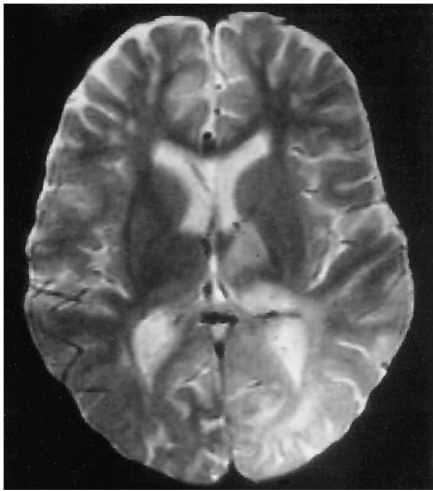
A 9-year-old boy with a 5-month history of SSPE, clinical stage G:IIA. An MR study obtained at admission (not shown) revealed only mild focal subcortical high-T2 white matter changes. Four months later, with the patient at clinical stage G:IIIB, T2-weighted (2000/80/1) MR image shows progress of high-intensity white matter changes, slight atrophy (MR stage 3), and extensive gray matter changes involving the left temporal (not shown) and parietooccipital regions. High T2 signal changes were also present in the left thalamus.
